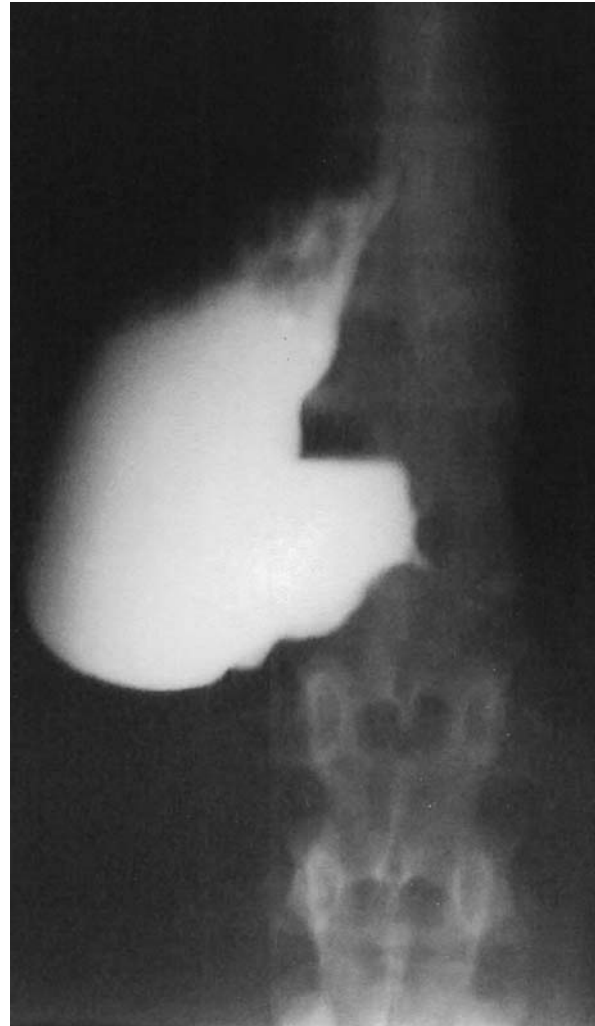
S-shaped dilated esophagus in barium X-ray
